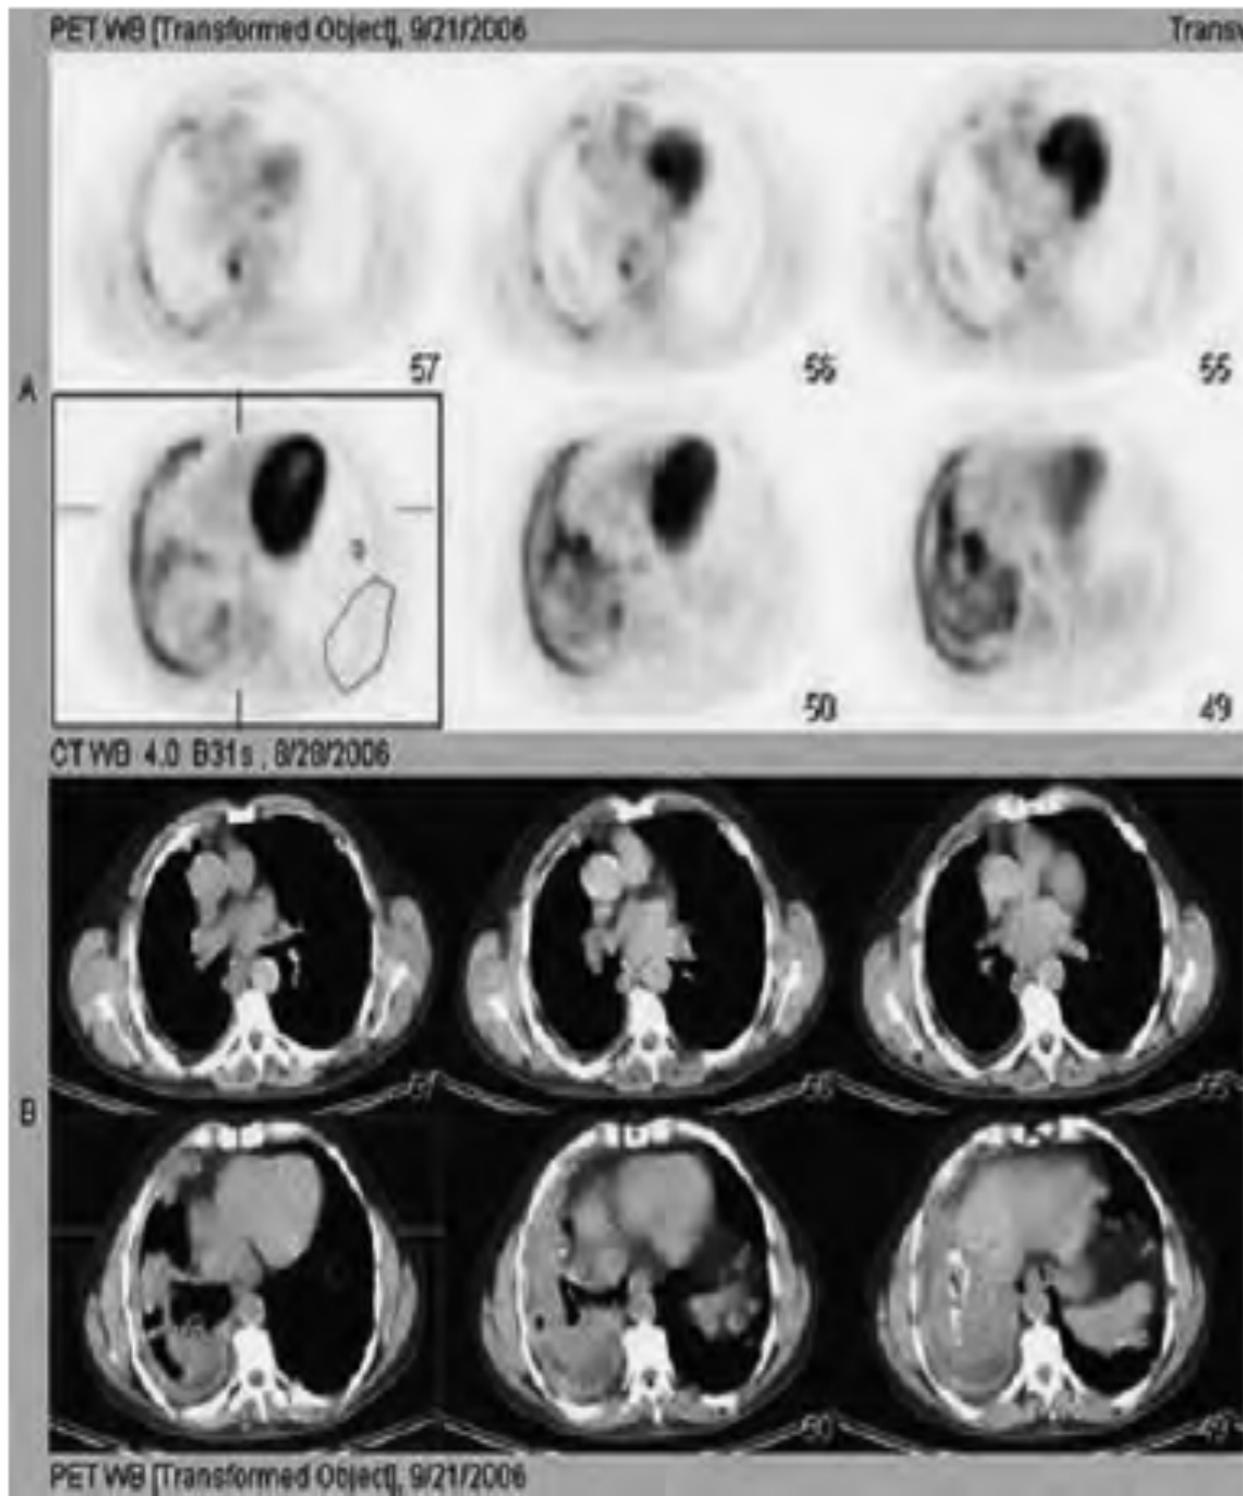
View of malignant pleural mesothelioma (SUVmax: 11.7).
